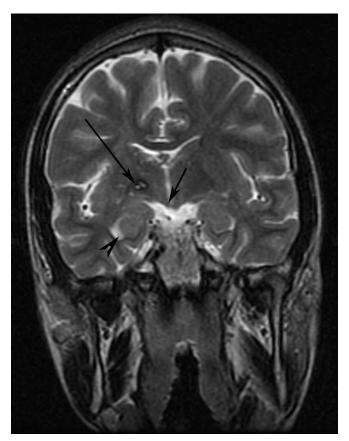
Coronal T2-weighted MRI (4000/124) demonstrates atrophy of the right mamillary body (short arrow) and hippocampus (arrowhead) as well as hemosiderin deposition in the region of the right internal capsule (long arrow).
